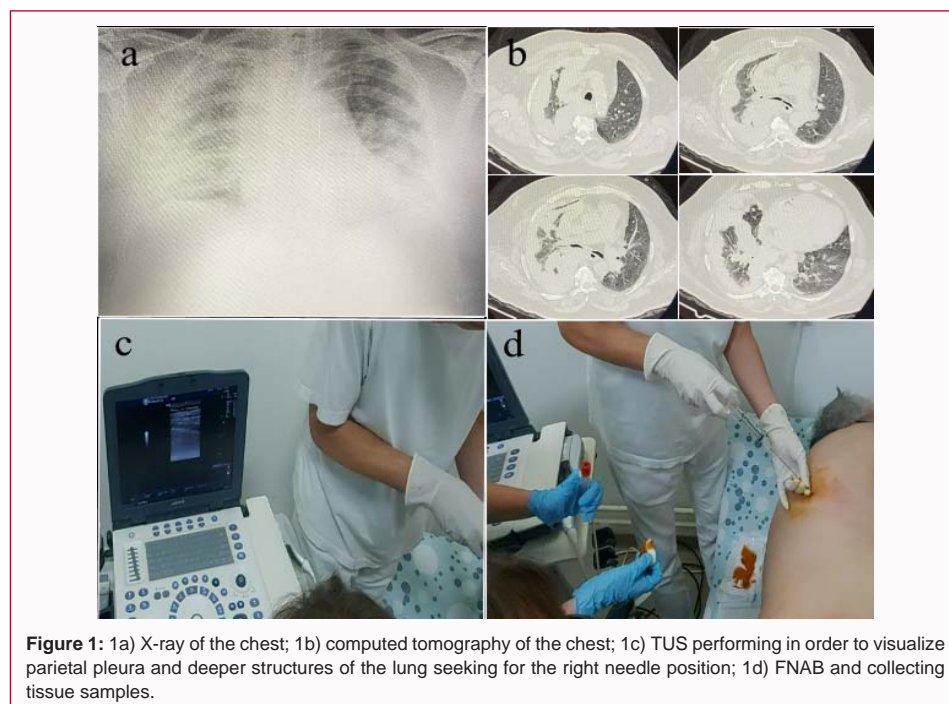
1a) X-ray of the chest; 1b) computed tomography of the chest; 1c) TUS performing in order to visualize parietal pleura and deeper structures of the lung seeking for the right needle position; 1d) FNAB and collecting tissue samples.
